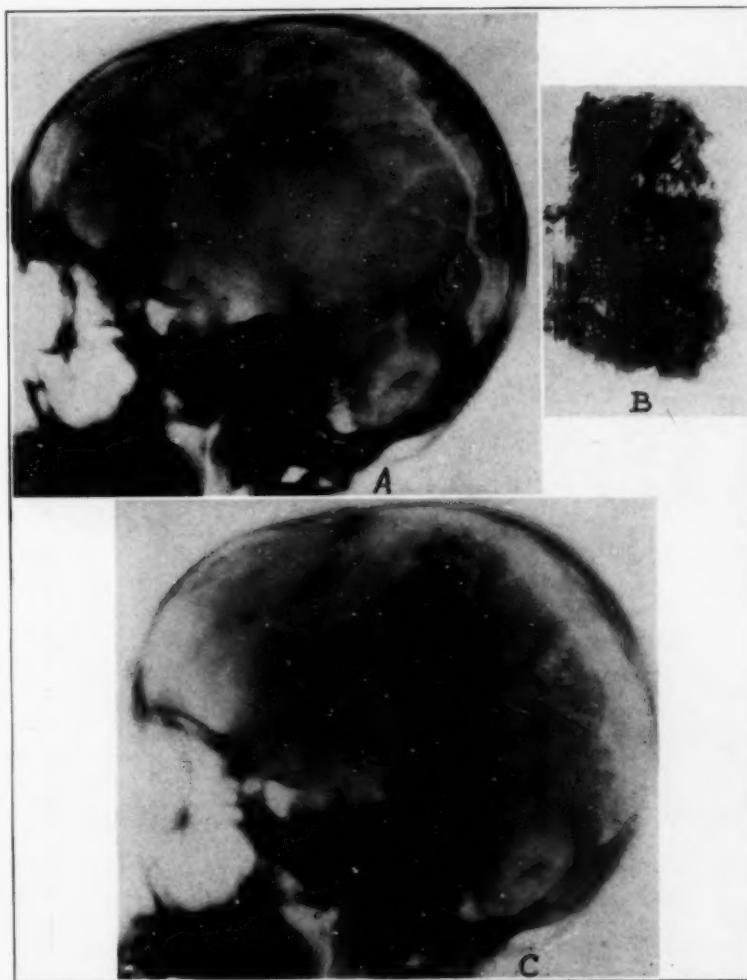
Endothelioma of left occipital lobe. Roentgenogram showing enlargement of left occipital diploic vein.
